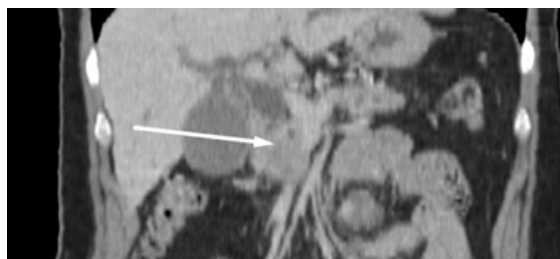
CT imaging demonstrates a pancreatic carcinoma
